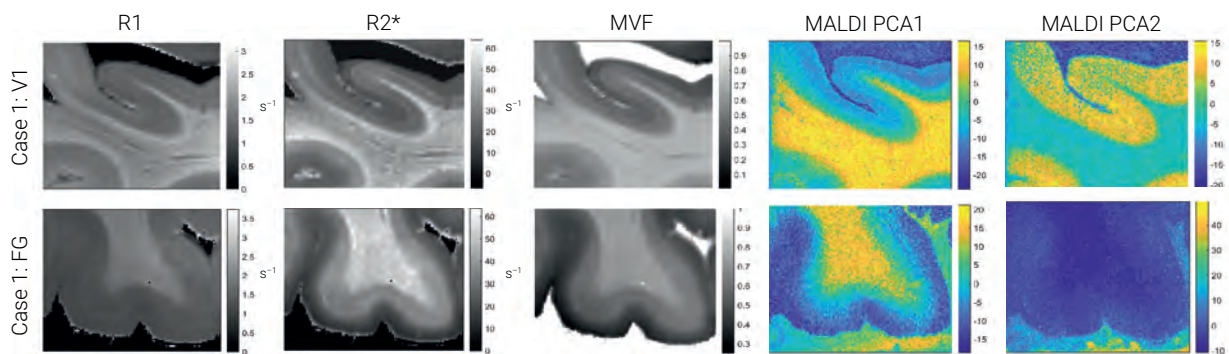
Comparison between myelin-sensitive quantitative MRI parameters and MALDI-MSI-based lipid concentration maps. Two rows correspond to two ROIs covering primary visual cortex (V1, top) and fusiform gyrus (FG, bottom). Quantitative maps of R1, R2* and macro-molecular volume fractions (MVF=1-PD; from left to right) are shown together with maps of two principal component analysis (PCA) scores obtained on the same ROI. The first PCA component is most pronounced in the white matter, reflecting the myelin content distribution in the ROI, while the second PCA component contains mostly cortical lipids. This demonstrates that the lipid composition of cortex and white matter clearly differs.
